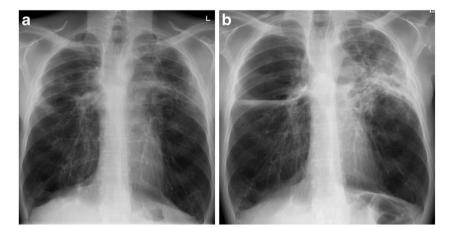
Progressive disease caused by chronic pulmonary aspergillosis and non-tuberculous mycobacterial co-infection. a Chest radiograph showing bilateral upper zone volume loss. There is ill-defined opacification in the left upper zone and some smooth pleural thickening laterally. Serum *Aspergillus* precipitins and *Aspergillus*-specific IgE were elevated but there was no clinical evidence of mycobacterial infection. b Follow-up radiograph, on oral itraconazole treatment, 4 months later showing progressive opacification in the left upper zone and an air-fluid level on the right. Sputum cultures were positive for *Mycobacterium xenopi* and *Mycobacterium kansasii* (serum *Aspergillus* precipitins remained high) and, despite the addition of anti-tuberculous therapy, the patient died 15 months later pulmonary aspergillosis. Persistent consolidation progressing to cavitation (with or without intracavitary material) and volume loss over time are the principal findings. In most patients, there is consolidation which is usually centred in the upper lobes [22, 28]. Not surprisingly, because of an upper lobe predilection and the similarity of constitutional features, a presumptive radiological diagnosis of reactivation tuberculosis is often made. Indeed, pulmonary mycobacterial infections of various sorts are one of the more commonly identified disorders associated with chronic pulmonary aspergillosis [22, 25-28]. It is worth emphasising that, in clinical practice, aspergillosis and non-tuberculous mycobacterial infection may co-exist [40-44] and this combination confers a worse prognosis (Fig. 2) [41, 44]. In the absence of treatment, consolidation caused by chronic pulmonary aspergillosis may progress, rarely causing complete opacification of a lung and volume loss [22] (Fig. 3).
